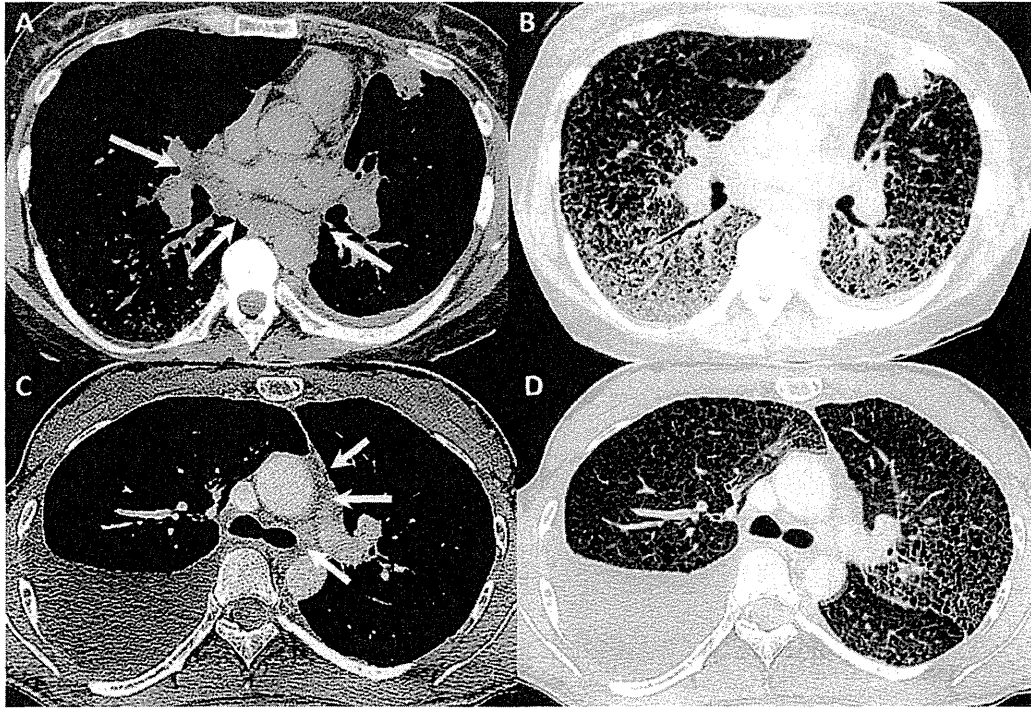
CT images of a thickened mediastinum with decreased density. (A, B) CT images of a 41-year-old female with S-LAM, and (C, D) CT images of a 30-year-old female with S-LAM. The CT images of both patients show thickened mediastina with decreased density (arrows). Note the coexistence of ground-glass attenuation and pleural effusion.
